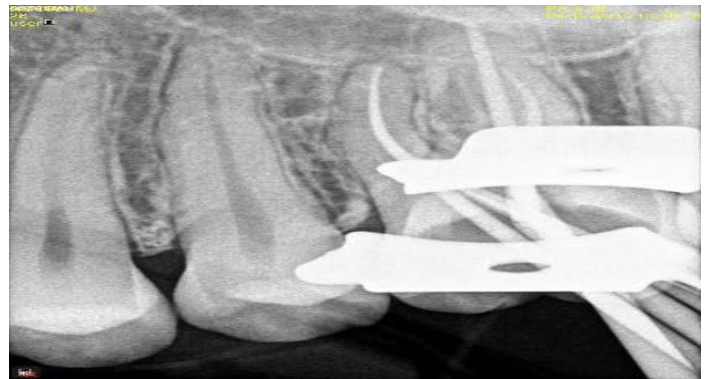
d: Master cone radiograph
